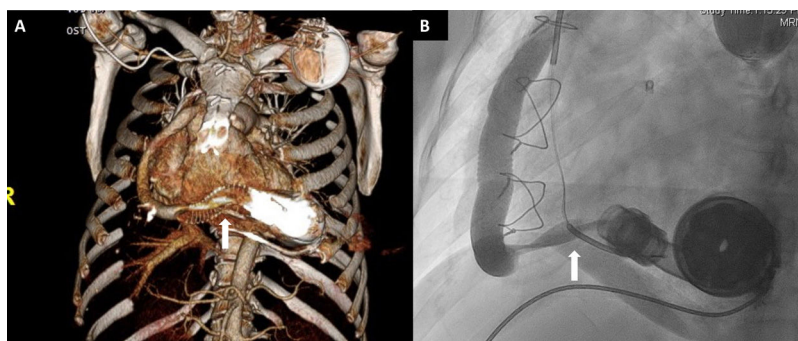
A: chest computed tomography scan with 3-dimensional reconstruction suggesting a twist of the outflow graft (arrow). B: angiogram of the outflow graft confirming a twist in the last portion near the connection with the pump (arrow).
